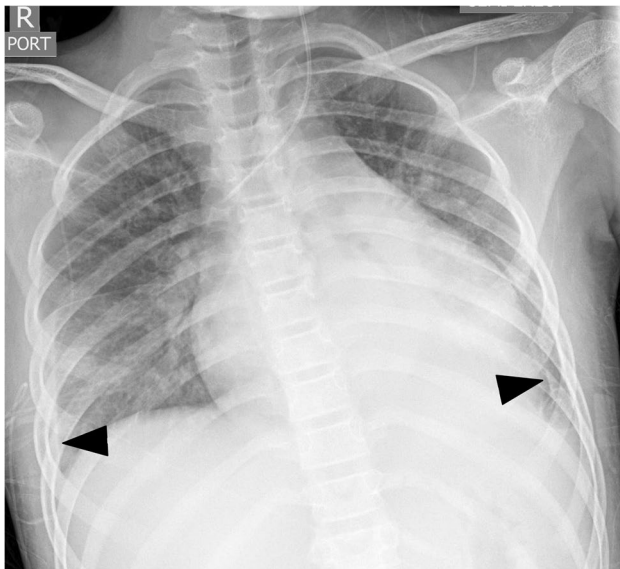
Multisystem inflammatory syndrome in children (MIS-C) in a 9-year-old girl who presented with fever and abdominal pain. Anteroposterior chest radiograph shows a mildly enlarged cardiac silhouette, interstitial edema with increased interstitial markings and hazy pulmonary opacity, worst at the bases, and bilateral small pleural effusions (*arrowheads*)
